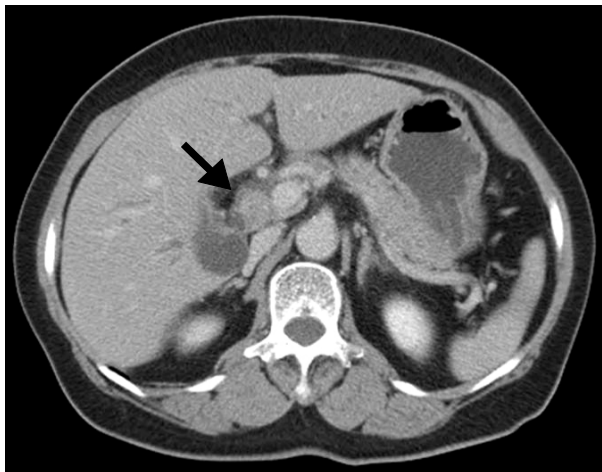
An abdominal computed tomography revealed a 2 cm sized enhancing mass (arrow) in the extrahepatic bile duct.
